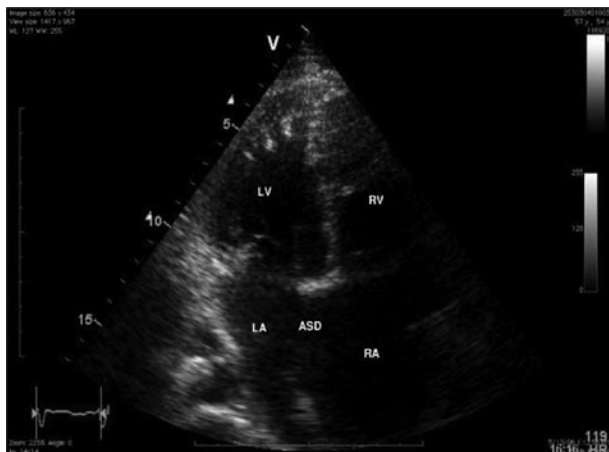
Two dimensional transthoracic echocardiography in four chamber view showing the dilated right ventricle (RV),- right atrium (RA) compared to the left ventricle (LV) and left atrium (LA), with a large primum atrial septal defect (ASD)
